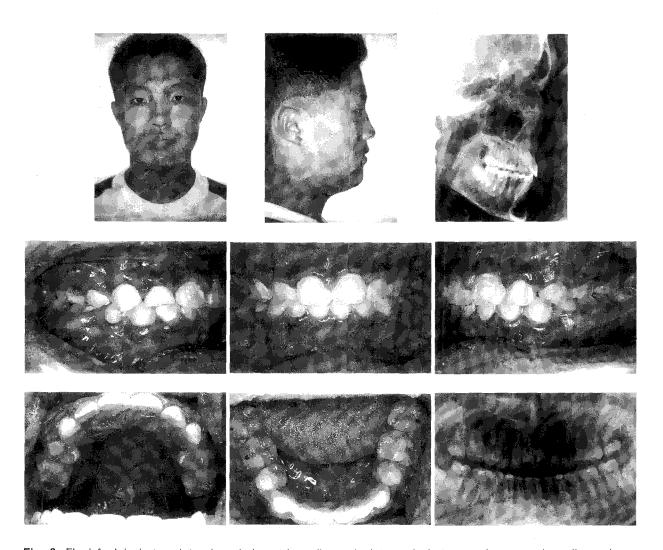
Final facial photos, lateral cephalometric radiograph, intraoral photos, and panoramic radiograph.
